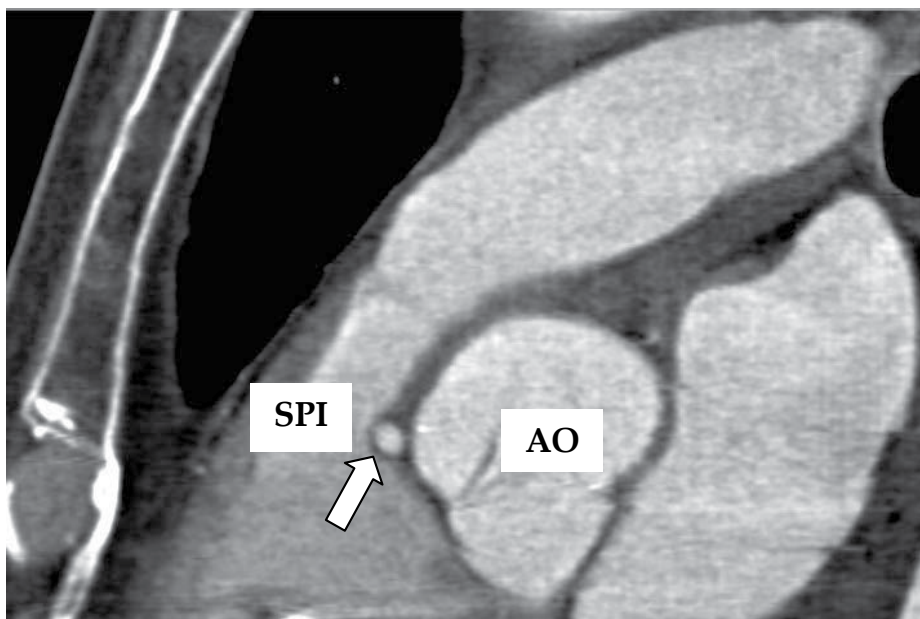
Computed tomography imaging of an ectopic left main coronary artery (arrow) arising from the right sinus with a retroinfundibular course. AO: aorta, SPI: subpulmonary infundibulum.
